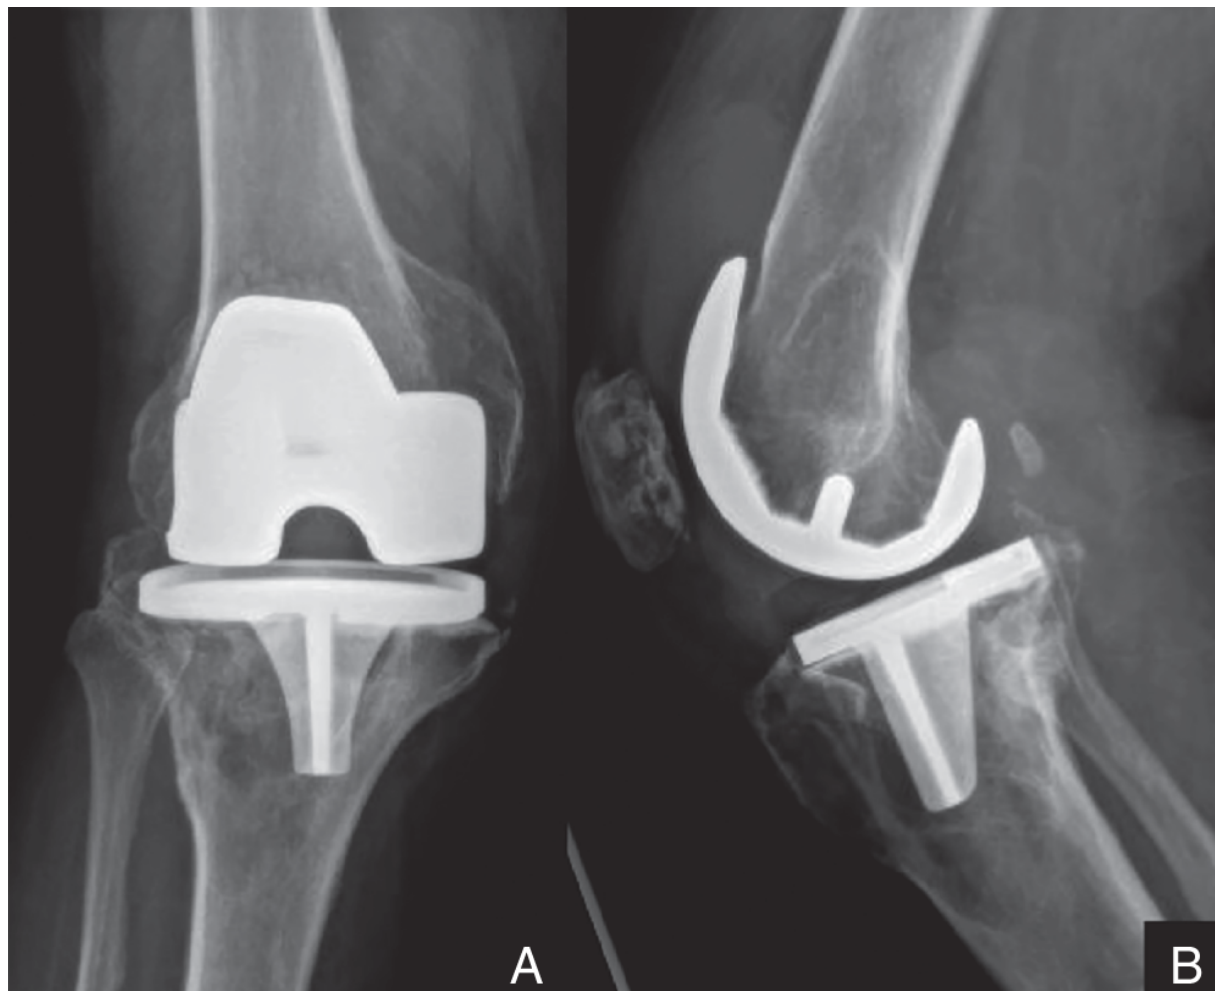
Preoperative radiographs demonstrating a loose primary TKA with significant loss of tibial bone stock.
